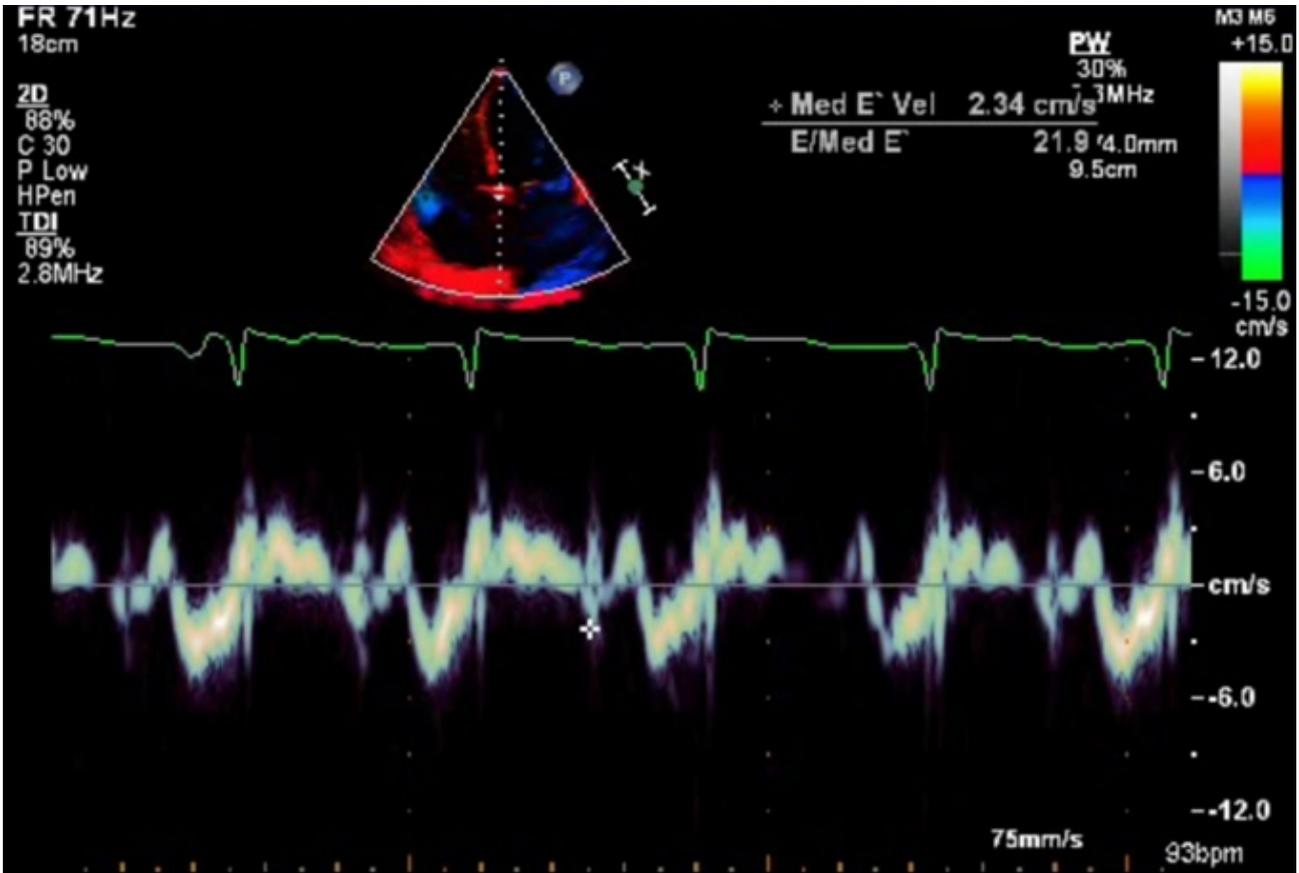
Tissue Doppler velocities consistent with reduced longitudinal systolic shortening (reduced S' velocity) and diastolic dysfunction (reduced E' velocity)
